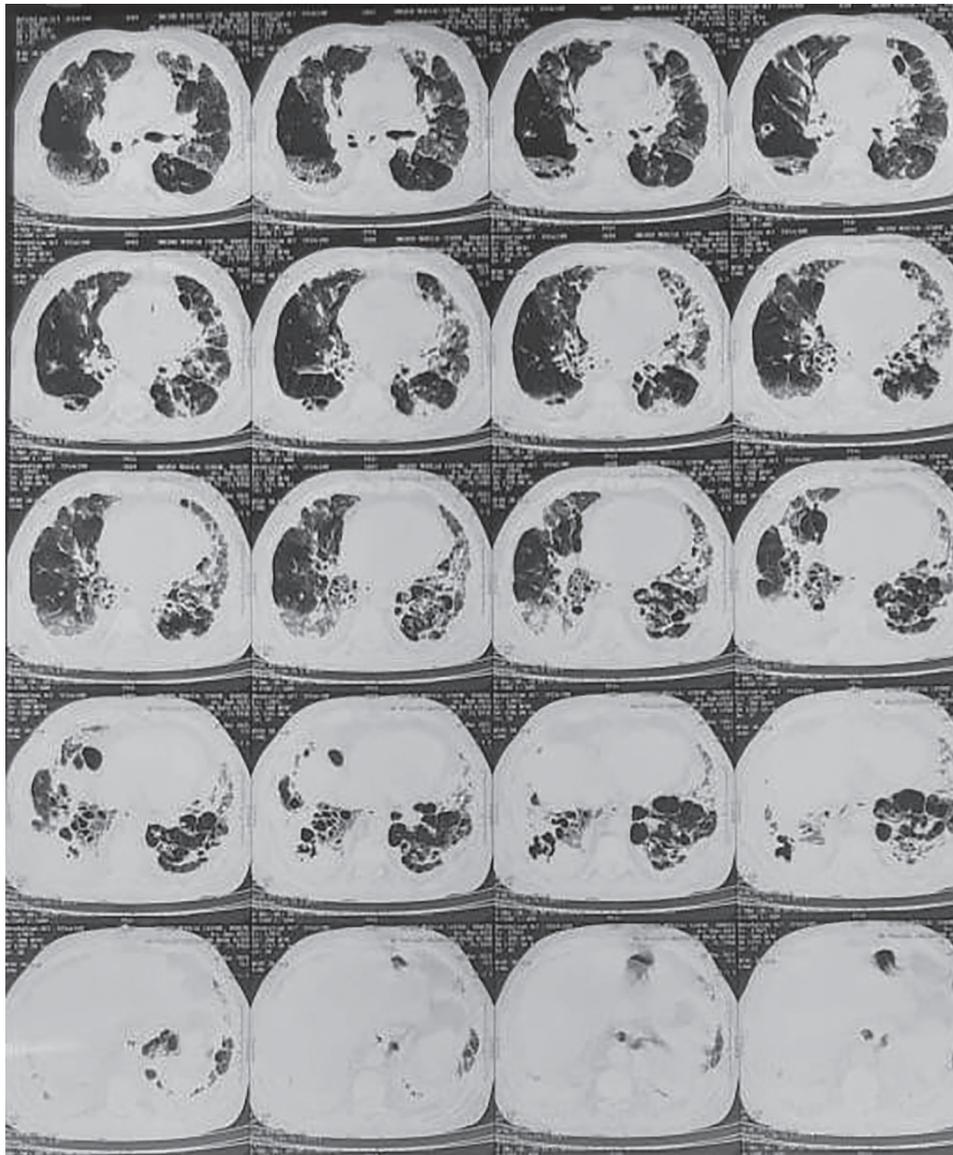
HRCT thorax showing multiple cavitory lesions
